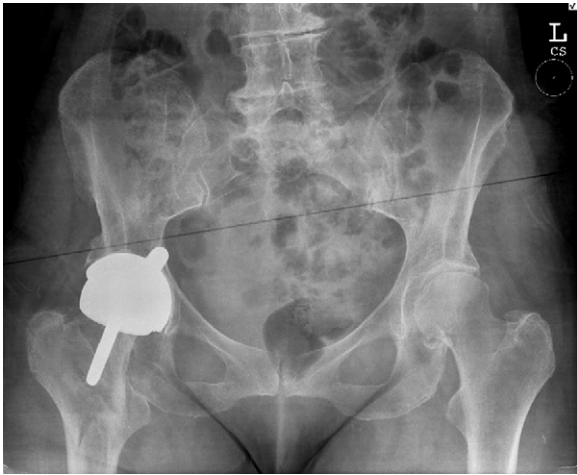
Patient 1 radiograph AP pelvis at presentation.
